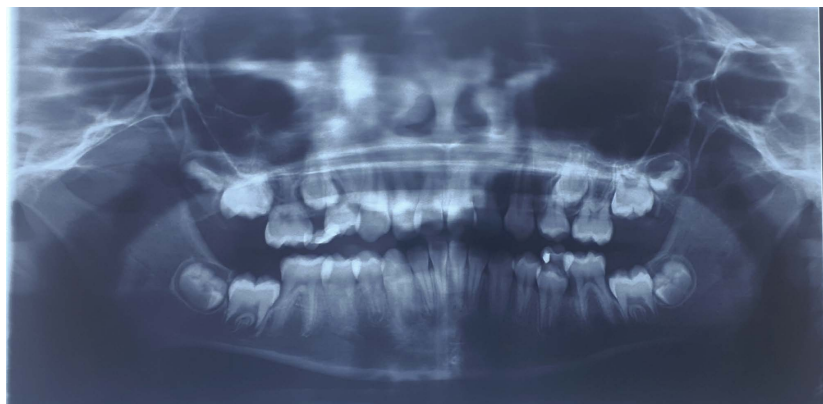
Radiography revealing bilateral impacted maxillary second premolars.
